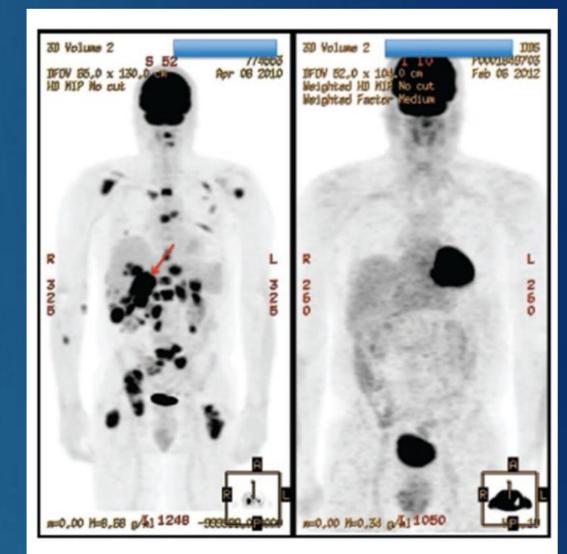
PET/CT demonstrating initial tumor site (red arrow) with widespread metastases prior to treatment (left). Follow-up scan shows remarkable abscopal effect with dramatic improvement of metastases.⁶
